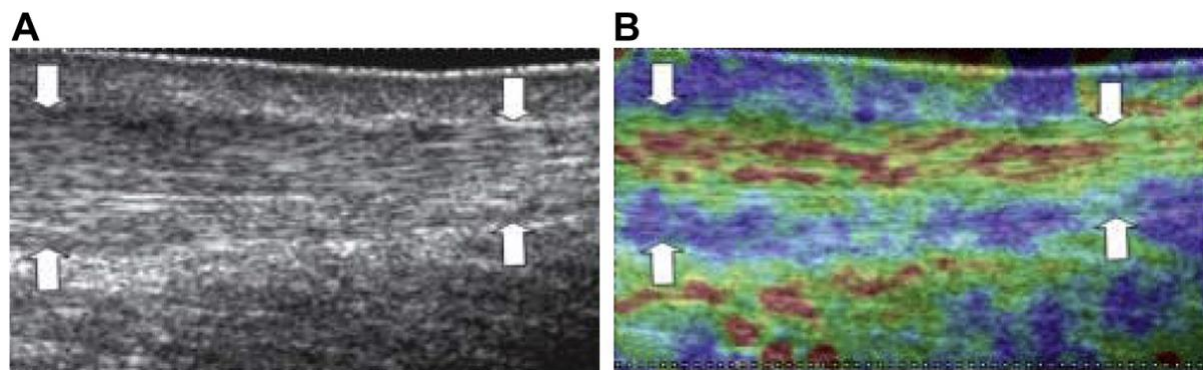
Comparative images of a symptomatic Achilles tendon of a 62 year old man. (A) A longitudinal B-mode ultrasound image (arrows showing thickened midportion). (B) A longitudinal strain elastogram showing red section in midportion of tendon (red equates to softness and associated viscoelastic changes indicating pathology). Image from De Zordo et al (De Zordo et al., 2009, p. W137)
